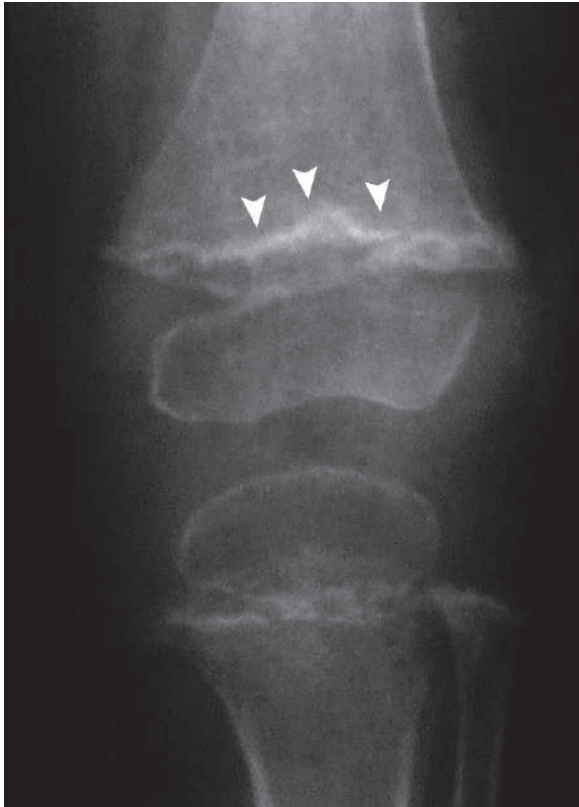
Anteroposterior plain knee radiograph in another child with scurvy shows dense sclerotic metaphyseal line (*White line of Frankel*). Notice the diffuse osteoporosis affecting the entire knee joint
